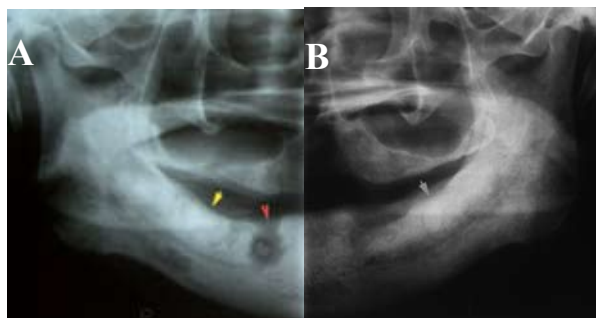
Parts of panoramic radiographs showing FOD lesions. A: The lesion at the right mandible presented with cellulitis (yellow arrow). A poorly-demarcated radiolucent area close to the right mental foramen corresponded to the purulent discharge (red arrow). B: The silent FOD lesion at the left mandible (grey arrow).
